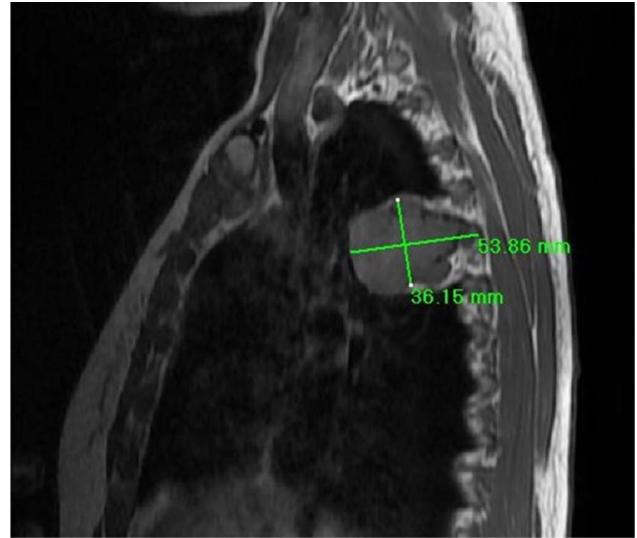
A thoracic sagittal plane T1 weighted magnetic resonance imaging show a heterogeneous mass at the right fifth–sixth costo-vertebral angle measuring 53–36 mm, 1 year preoperatively.
